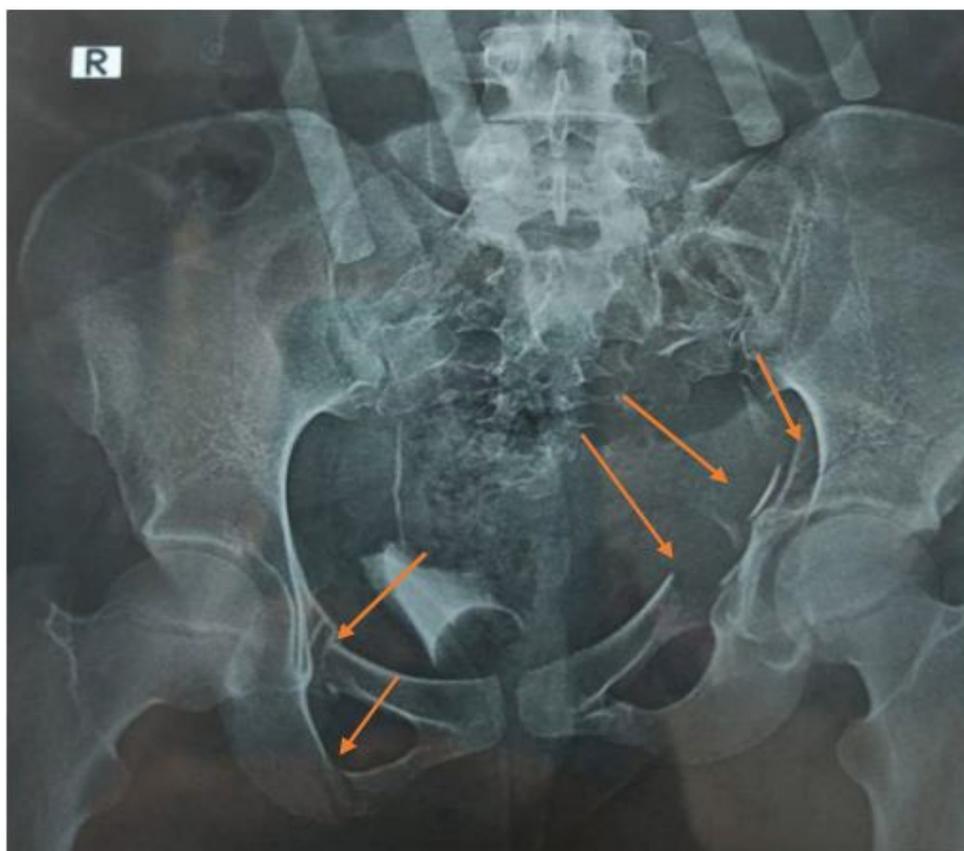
X-ray film of a girl 16.5 years old, showing multiple fractures (arrows) in the pelvis as a result of jumping from 2nd floor in an attempt of suicide due to school failure.
